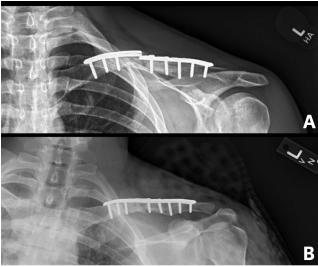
A. Xray (AP) of left clavicle 2.5 months after initial surgery showing remaining midshaft clavicle fracture with midplate breakage, and no loss of fixation; B. Radiograph taken after second revision surgery demonstrates a reduced clavicle fracture fixed with 10-hole superior clavicular locking plate.
